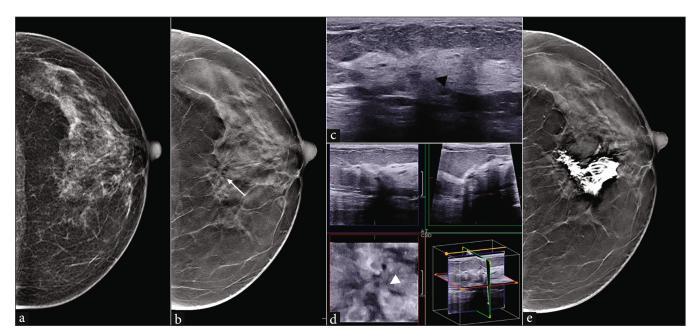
A 50-year-old female with apocrine metaplasia on biopsy. (a) 2D CC and (b) 3D CC mammography views of the left breast show isolated AD in the central quadrant only on tomosynthesis (white arrow in b). (c) Greyscale targeted ultrasound at 12 o'clock shows subtle posterior acoustic shadowing (black arrowhead). (d) 3D ultrasound shows radiating echogenic spicules with a simple anechoic cyst (white arrowhead) in the vicinity. (e) 3D CC view after injecting the iodinated contrast confirmed the sono-mammographic correlation. CC: Craniocaudal, AD: Architectural distortion.
